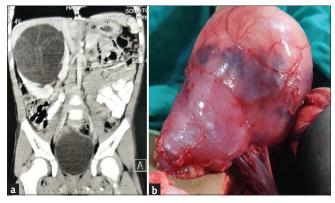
(a) Contrast-enhanced computed tomography showing right upper pole multicystic mass with spared lower pole and its vessels and (b) intraoperative picture with upper pole mass and spared lower one-third renal parenchyma
